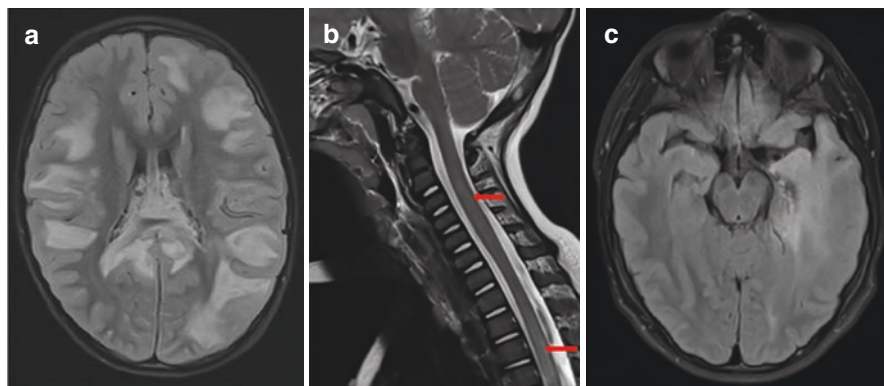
MRI Findings in Pediatric AIE. (a) Axial FLAIR imaging of a 5-year-old boy with acute disseminated encephalomyelitis demonstrating numerous, large, ill-defined hyperintensities within the white matter of the brain and (b) sagittal T2-weighted imaging of the cervical spine in the same patient showing patchy hyperintensities throughout the spinal cord (red arrows). (c) Axial FLAIR imaging of a 13-year-old boy with limbic encephalitis associated with LGI-1 antibodies demonstrating hyperintensities within the left medial temporal lobe
